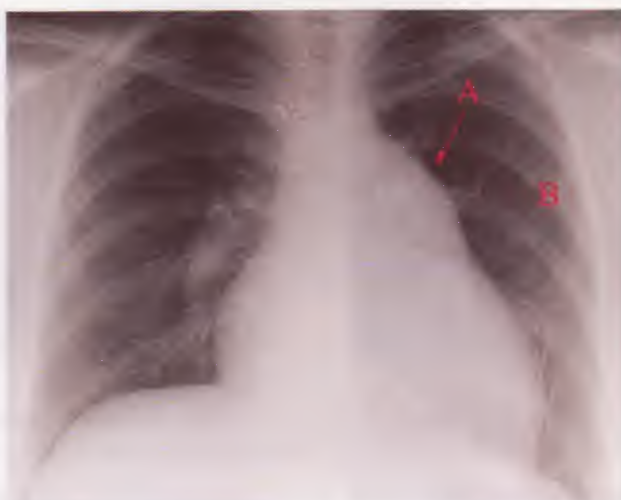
PA chest x-ray showing pulmonary hypertension with prominent pulmonary artery segment (A) and decreased pulmonary vascular markings (B)
